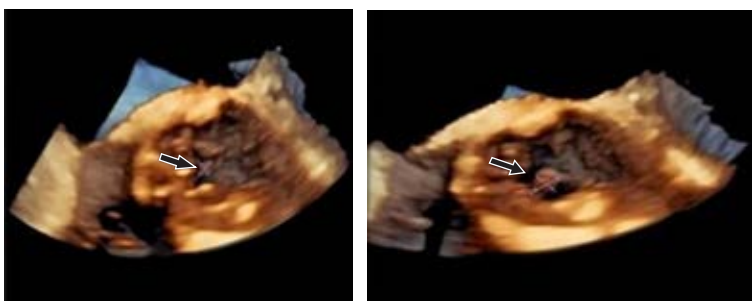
View showing a suggestive image of vegetation in 3D transesophageal echocardiogram.
